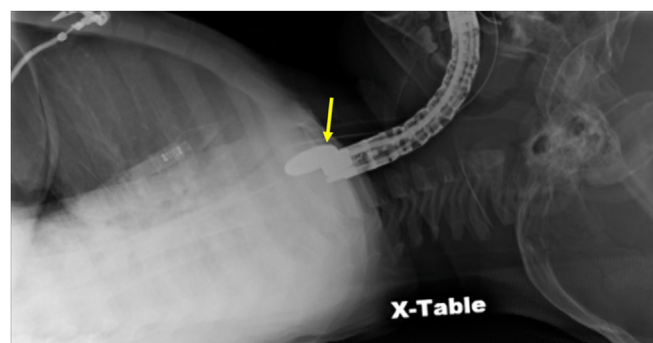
Lateral neck radiograph with a circular radiopaque foreign body (yellow arrow) adjacent to an endoscope that was unable to visualize the foreign body.
